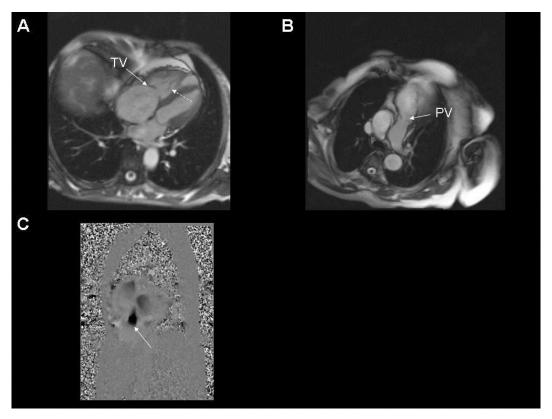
Cine Cardiac Magnetic Resonance Imaging.
